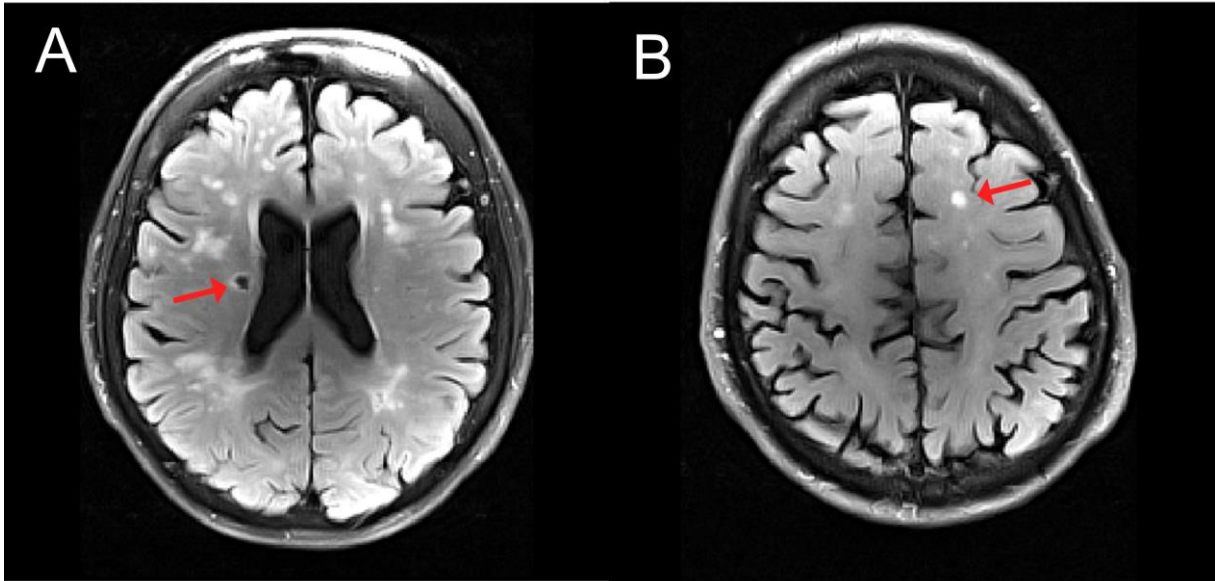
FLAIR image with examples for markers of structural changes in small vessel disease. Characteristic abnormality related to lacune (A) and white matter lesion (B).
